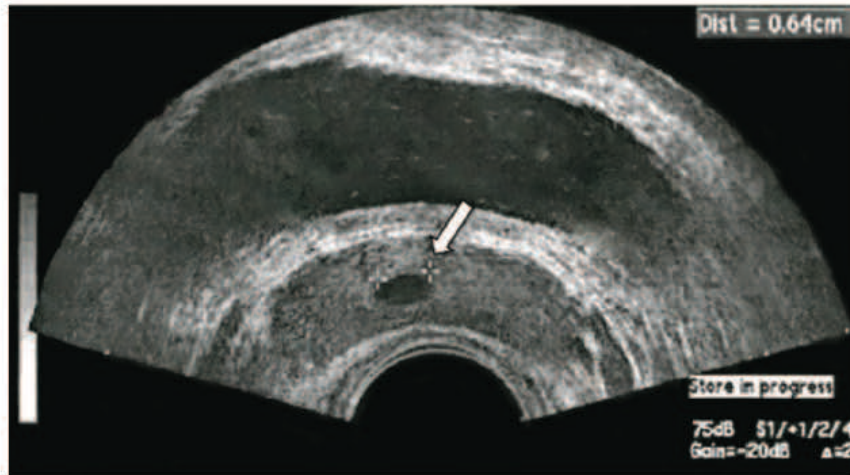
Transrectal Ultrasound (TRUS): coronal and sagittal sections. Note the dilated seminal vesicles (white arrow).
